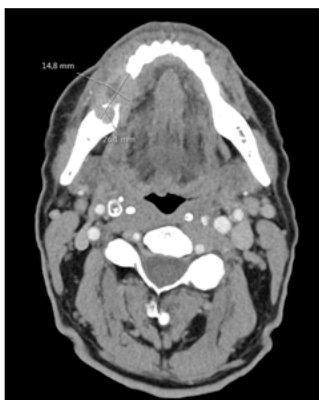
cT4a squamous cell carcinoma of the right mandible with bone invasion (1a) axial reconstruction a CT scan, (1b) pre-operative orthopantomography.
